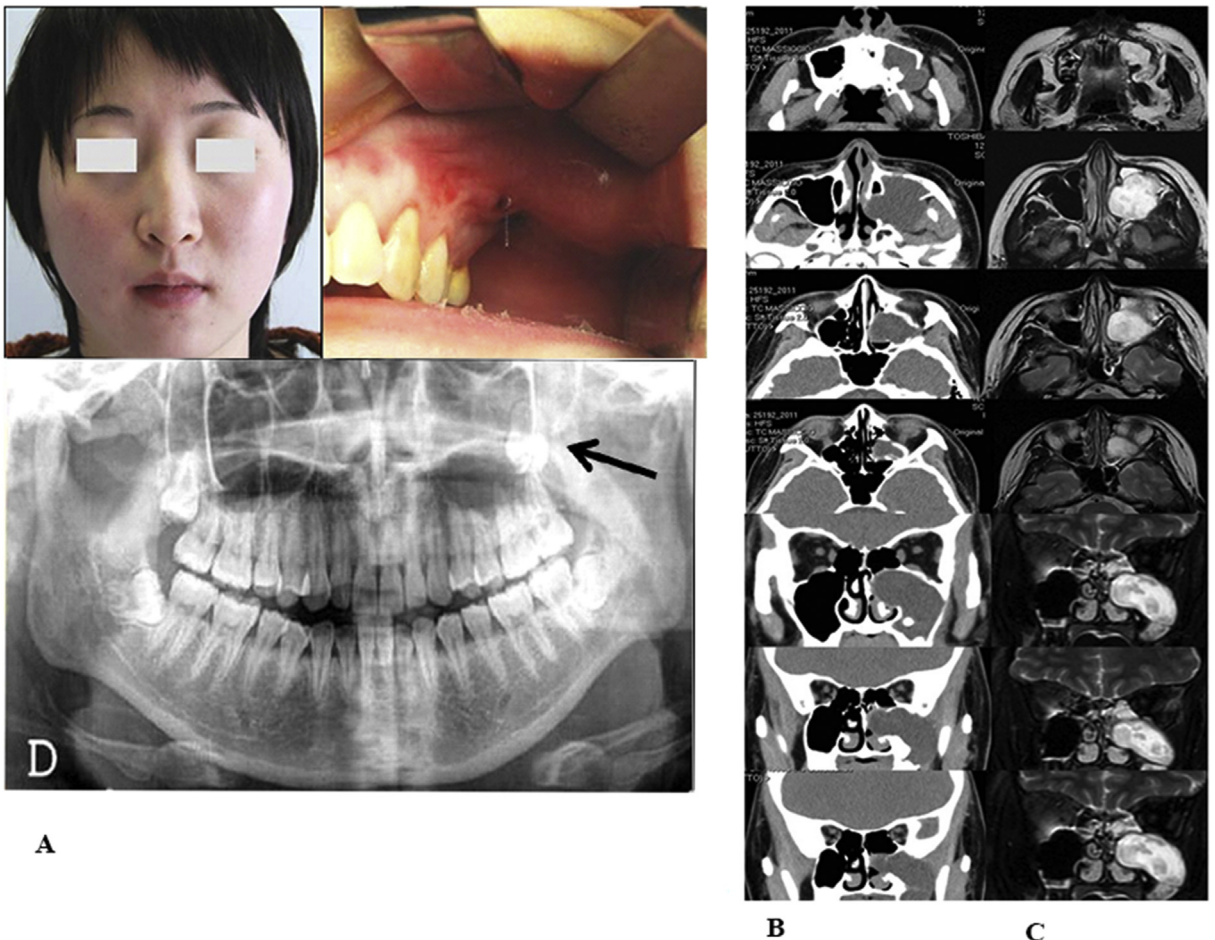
a. Clinical aspect of the patient at the admission and orthopantomogram x-ray: the black arrow shows the impacted superior third molar. b. integrated imaging study showing by CT (b) and MR (c) the very large extension of the follicular cyst with the involvement of the hard palate, the pterygo-maxillary region and the ethmoidal-orbital right structures, both on axial and coronal scan.
